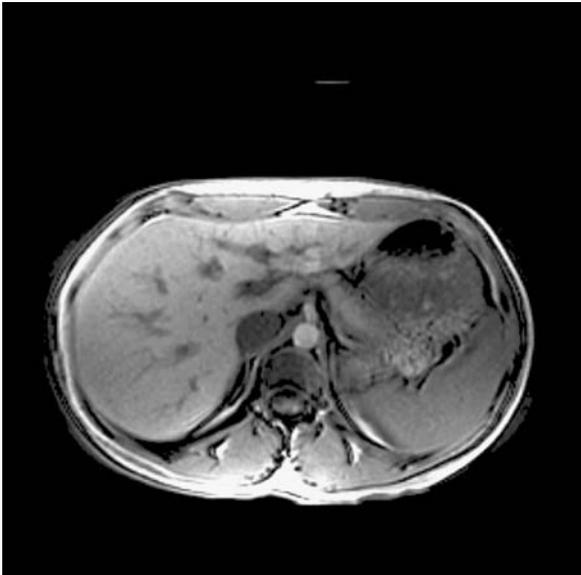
MRI of the liver after treatment showing complete resolution of the lesions
